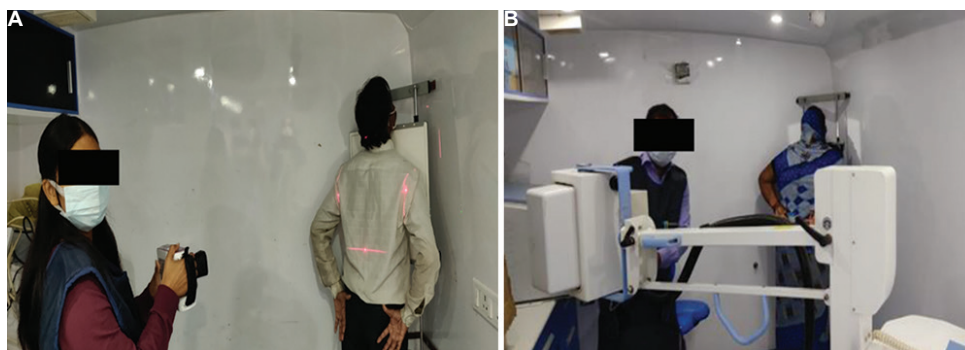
Photos of both machines and patient positioning. (A) mine 2 X-ray machine and patient positioning, (B) digital X-ray machine
